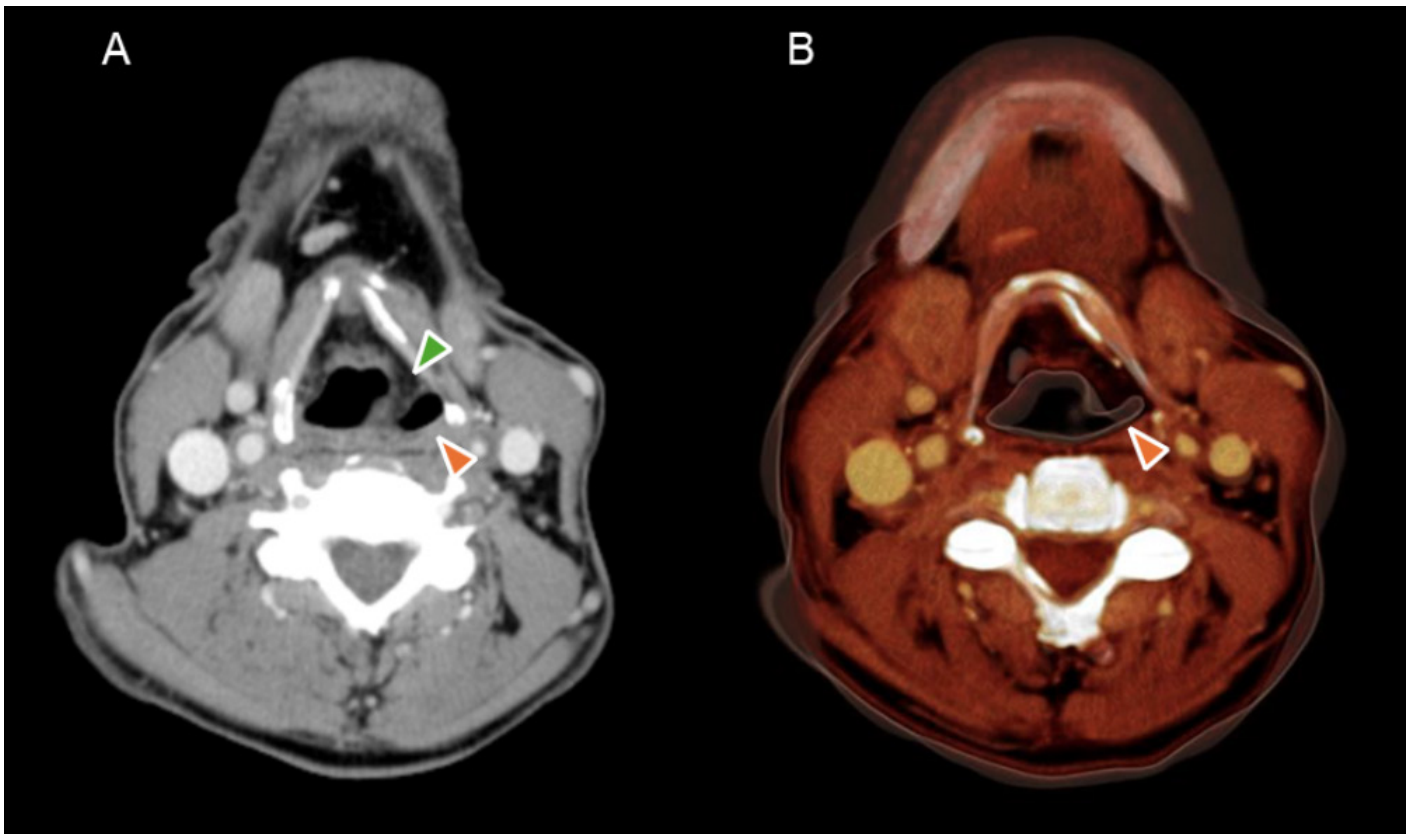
A computed tomography (CT) scan (A) and volume rendering reconstruction (B) of the neck demonstrate medial displacement of the ipsilateral aryepiglottic fold (green arrowhead) and dilation of the corresponding piriform recess (orange arrowheads).
